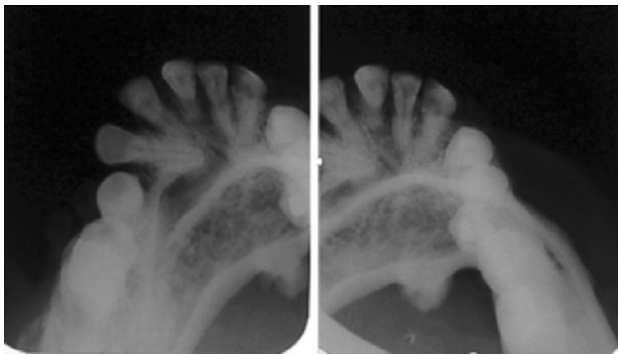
Occlusal radiograph of the case. Anterior teeth displacement is observed
